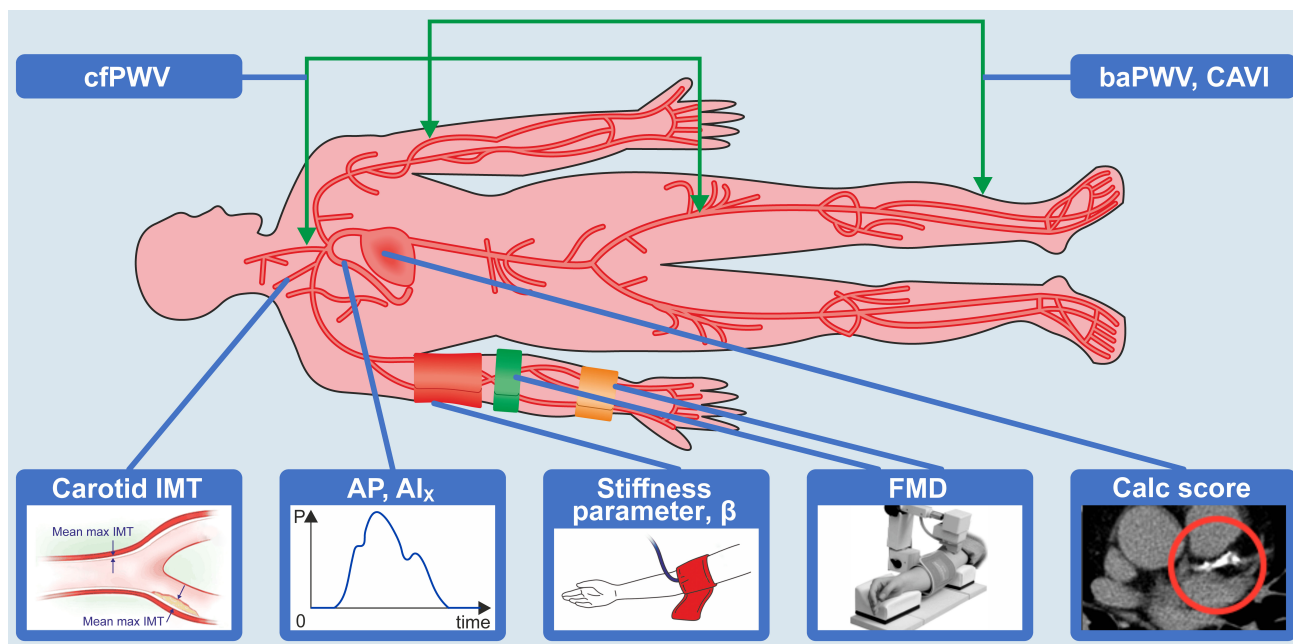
Using probes or a tonometer, the pulse wave velocity (PWV) can be measured between the carotid and femoral arteries (cfPWV) or brachial and ankle arteries (baPWV). The cardio-ankle vascular index (CAVI) can be obtained from blood pressure and heart-ankle PWV (haPWV) measurements. The carotid intima-media thickness (IMT) is measured using ultrasonography. The augmenting pressure (AP) and the augmentation index (AIX) are derived from the central arterial waveforms. The arterial stiffness parameter β is calculated using systolic and diastolic pressure values and the variation in the aortic diameter. Flow-mediated vasodilation (FMD) is a technique that uses ultrasonography and plethysmography to analyze changes in the forearm blood flow. Coronary artery calcification is assessed by computed tomography (CT).
